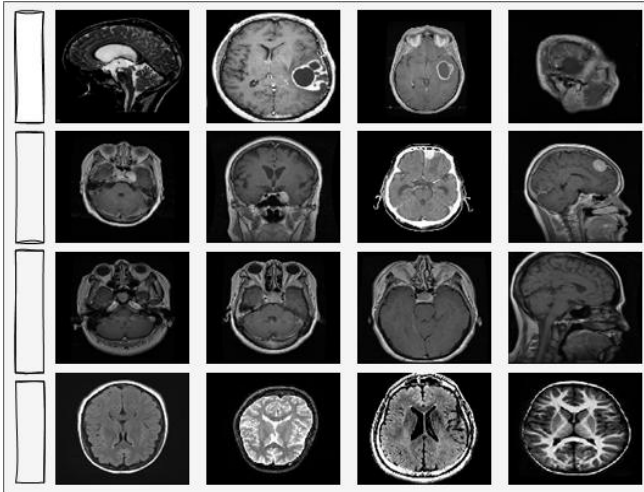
Representative MRI samples from the four brain tumor dataset classes.
